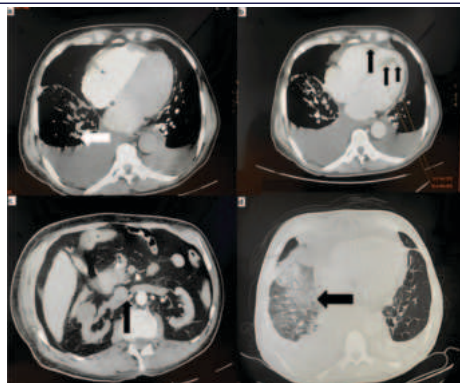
CT angiography scans Imaging for a 73 year old Moroccan male patient affected by COVID-19.
